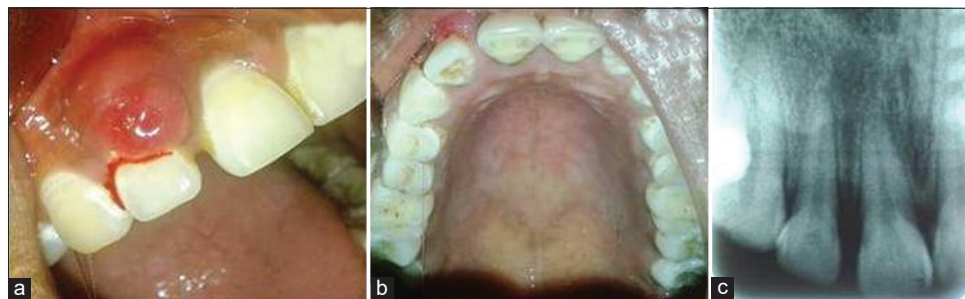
Clinical intraoral photograph of the patient showing well-circumscribed lesion on maxillary labial gingiva i.r.t 12 (a and b) and intraoral periapical radiograph of the patient showing interdental bone loss between 11 and 12 (c)
